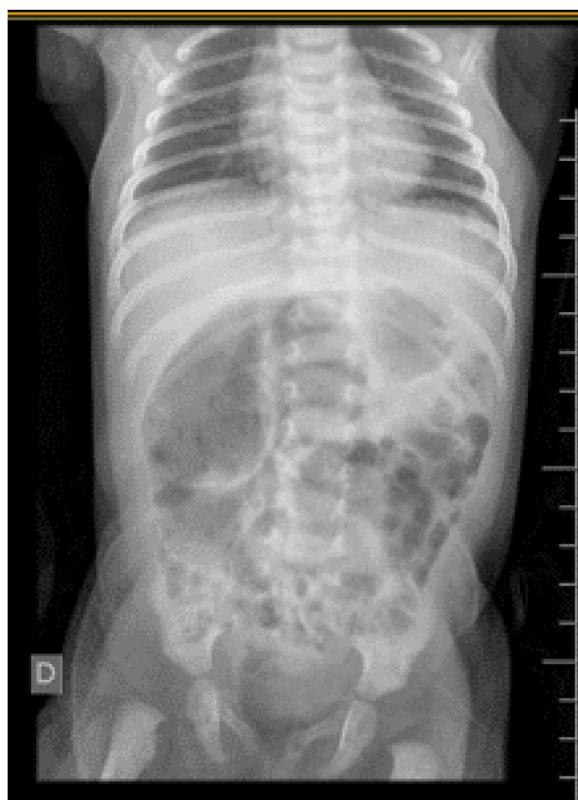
Simple X-ray of the abdomen, showing a small intestine loop distension.
